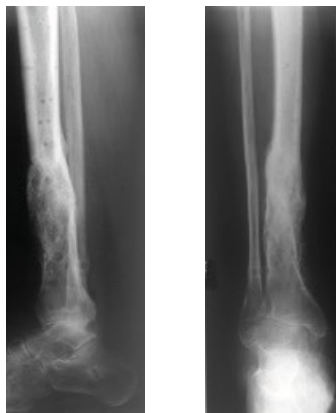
12-months postoperative radiographs demonstrating tibial healing
